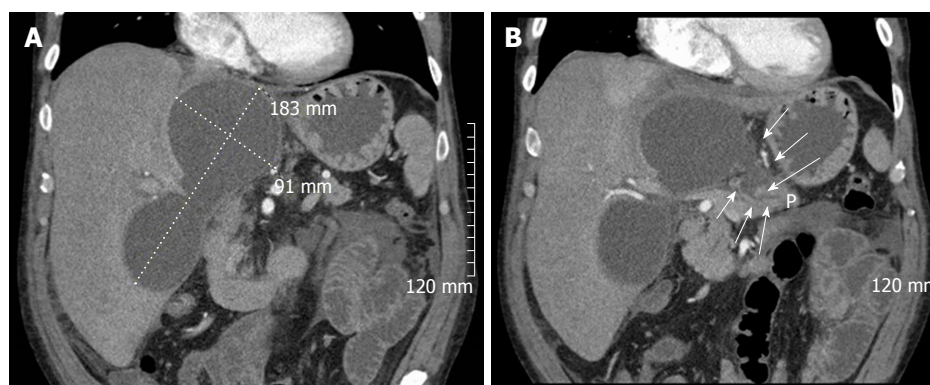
Abdominal computed tomography images showing bilobed intrahepatic pancreatic pseudocysts (A), including connection to main pancreatic duct (B, arrows).
